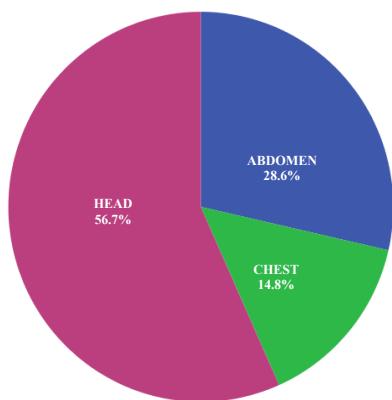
Types of CT examination performed on the subjects.
